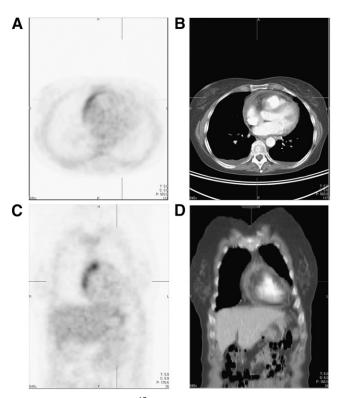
Transverse ¹⁸F-FDG PET slice (A), corresponding transverse CT slice (B), coronal ¹⁸F-FDG PET slice (C), and corresponding coronal CT slice (D). The irregular increased ¹⁸F-FDG uptake in ventral portion of pericardium adjacent to right ventricular wall would not have been recognized in the otherwise moderate to high ¹⁸F-FDG uptake ventral in right ventricular wall. Both transverse and coronal CT slices show thickened pericardium ventral in right ventricular wall, up to 8 mm.
